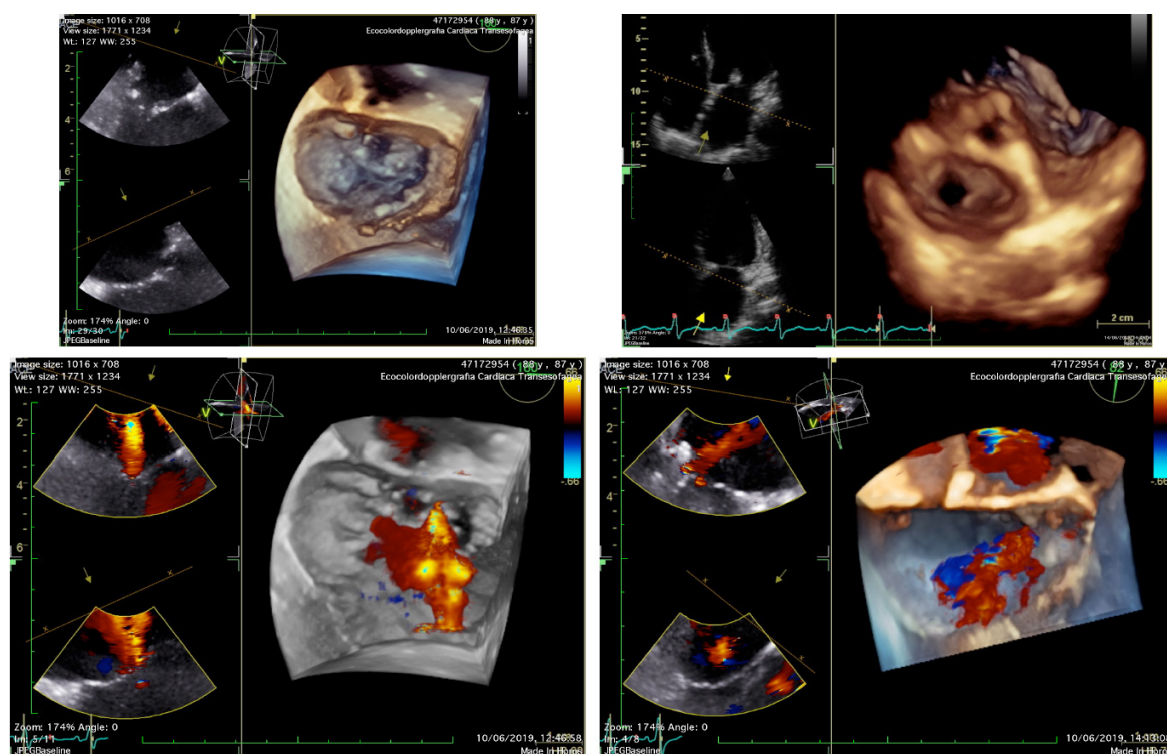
Periprocedural three-dimensional transesophageal echocardiography evaluation of mitral valve showing a pre-procedural severe functional mitral regurgitation with a holosystolic central jet and a consistent post-procedural reduction of the mitral regurgitation grade with the typical “double-orifice” valve
